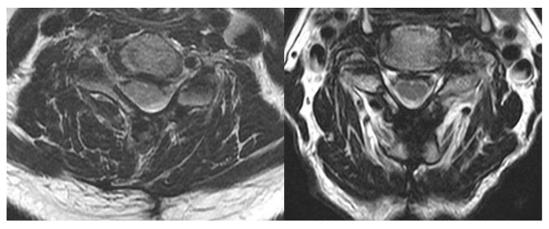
Influence of surgical techniques on soft tissues. The influence of endoscopic surgery (left) on the soft tissues differs substantially from that of conventional laminoplasty (right). MRI shows no changes of fatty degeneration in the paravertebral muscles after CMEL. Spine
